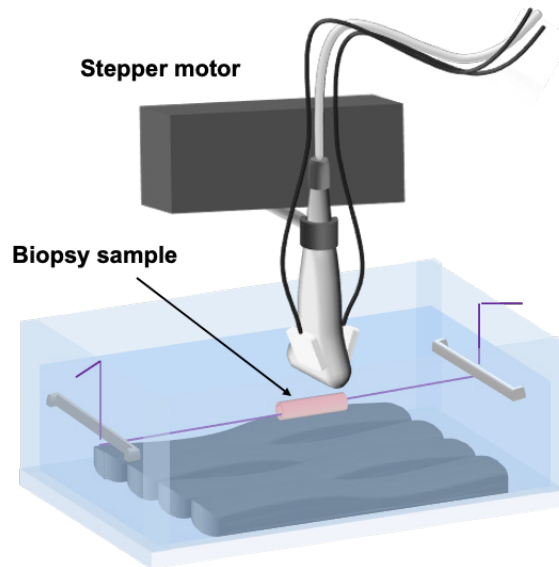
The photoacoustic scanning setup used to examine the biopsy samples. The sample is mounted in a container filled with balanced saline solution, with an ultrasound-attenuating material in the bottom. The transducer is fixed to an adjustable arm and is driven by a linear stepper motor.
